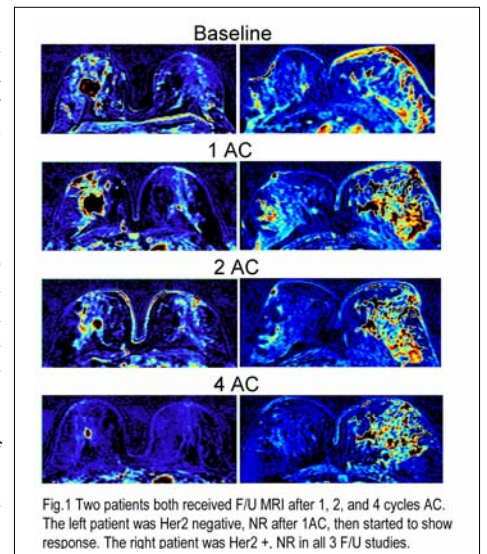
Two patients both received F/U MRI after 1, 2, and 4 cycles AC. The left patient was Her2 negative, NR after 1AC, then started to show response. The right patient was Her2 +, NR in all 3 F/U studies.
